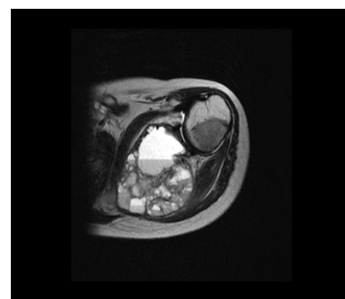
B) MRI scapula show GCT with secondary aneurismal bone cyst
